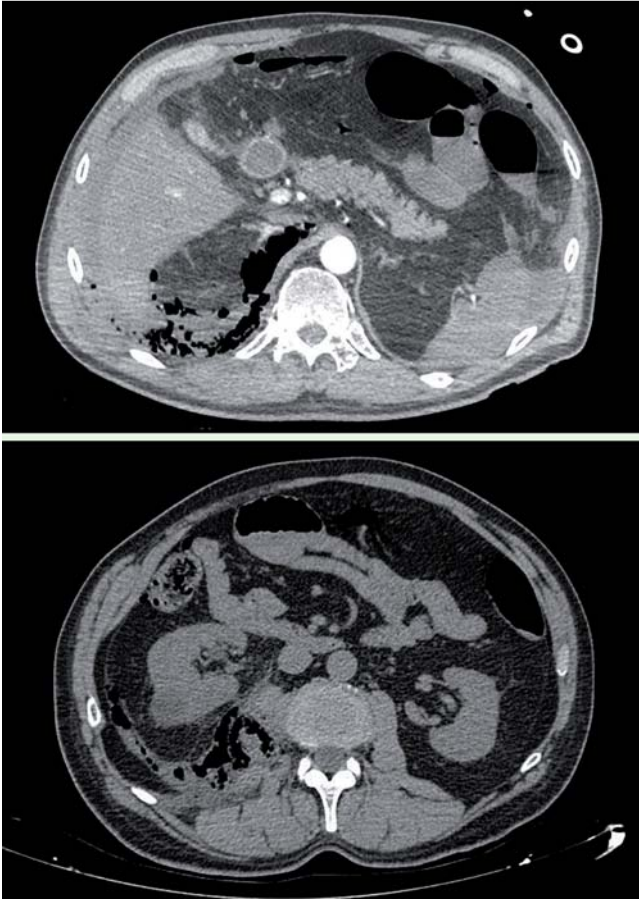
Abdominal computed tomography (CT) scan images in a previously healthy adult post-polypectomy showing a retroperitoneum, with the emphysema also involving the right psoas muscle.
